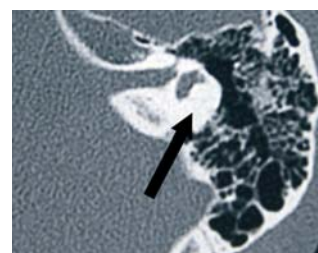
Patient 2; axial CT scan of the left lateral semicircular canal with ossification zone (arrow).
